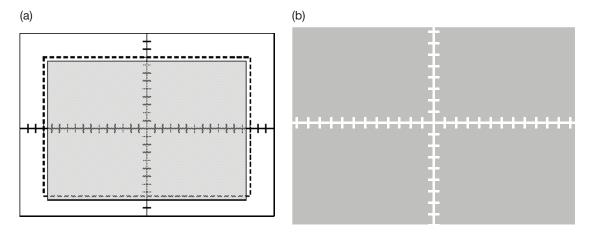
(a) Example of a beam alignment test object. The boundaries of the light field are shown by the dashed line; the x-ray field is shown as grey. (b) Example of a digital test object image.
